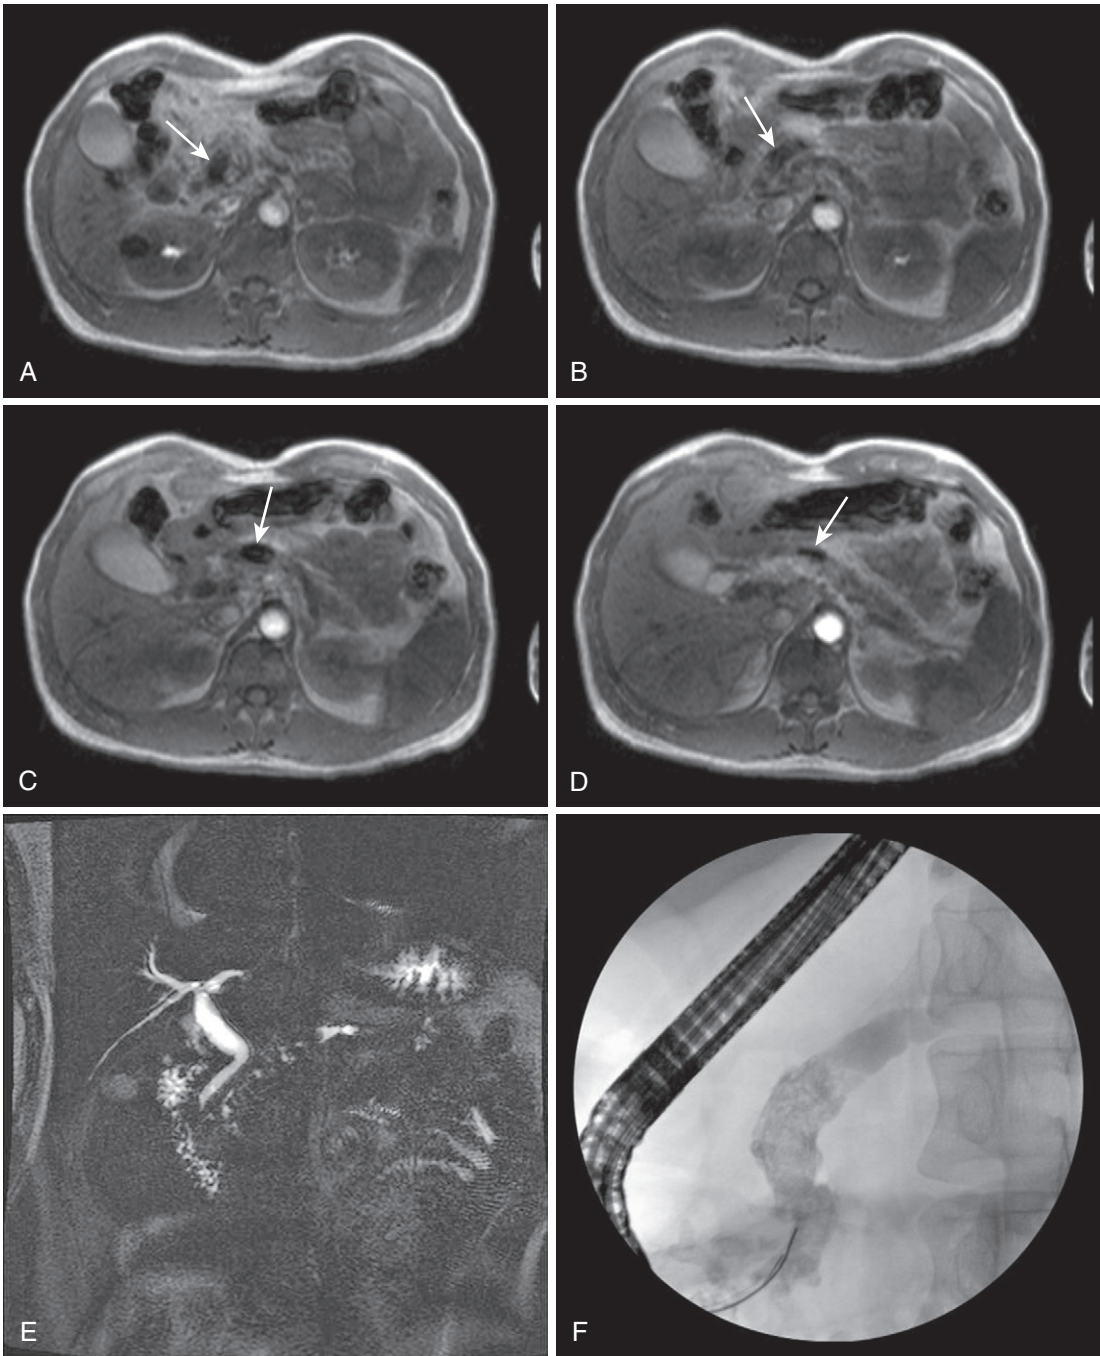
Hereditary pancreatitis. Four in-phase T1-weighted gradient recalled echo (A–D) and coronal thick-slab maximal intensity projectional MRCP (E) images through the pancreas demonstrate blooming within the head and proximal body of an atrophic pancreas with decreased T1-weighted signal intensity related to ductal calcification (*arrows*), better seen on the fluoroscopic spot radiograph (F), in a patient with hereditary pancreatitis.
